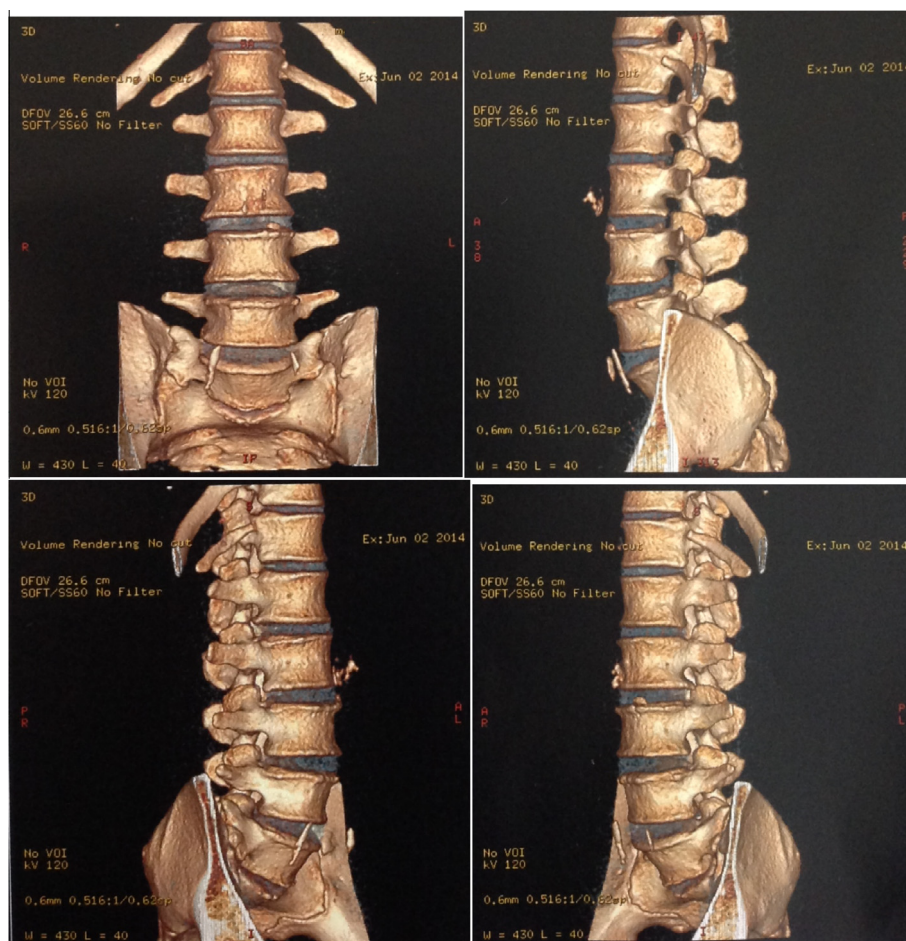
Colored 3D computed tomography (CT) scans of the lumbo-sacral spine with lateral meningoceles showing multiple frontal and side views. Osteophyte formation can be seen at the L1/2 level, adjacent to the right L1 nerve root as it exits the neural foramen. On the left side at the L1/2 level, a large well circumscribed paraspinal cystic lesion lying within the left psoas muscle is present which appears continuous with the left L1 neural foramen representing a lateral meningocele. Furthermore, a broad based left foraminal and far lateral disc osteophyte complex abutting the exiting left L2 nerve root is evident at the L2/3 level. At the L3/4 level, there was a broad based central and left paracentral disc protrusion resulting in moderate asymmetric canal stenosis.
